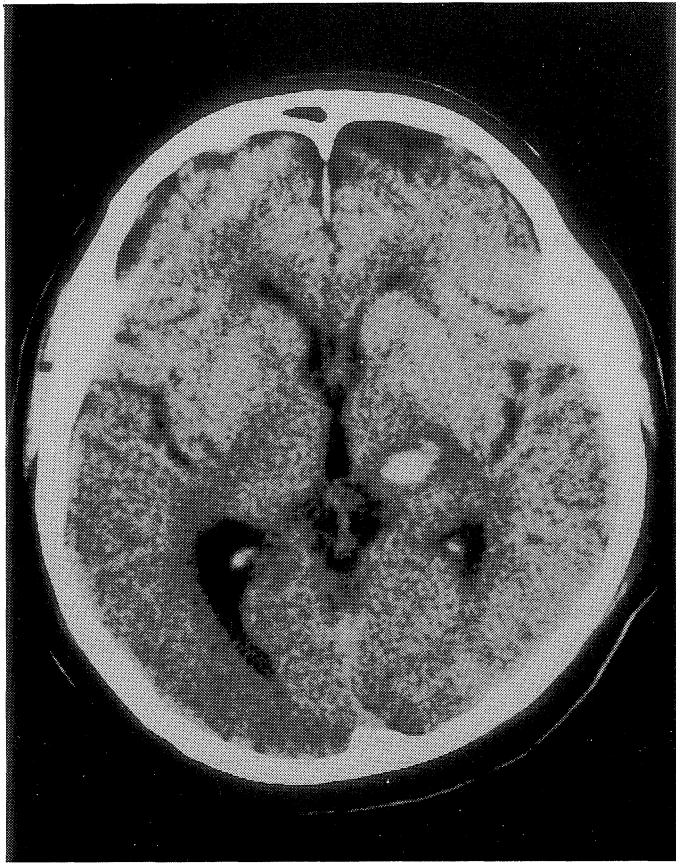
Computed tomography (CT) reveals the right small thalamic hemorrhage.
